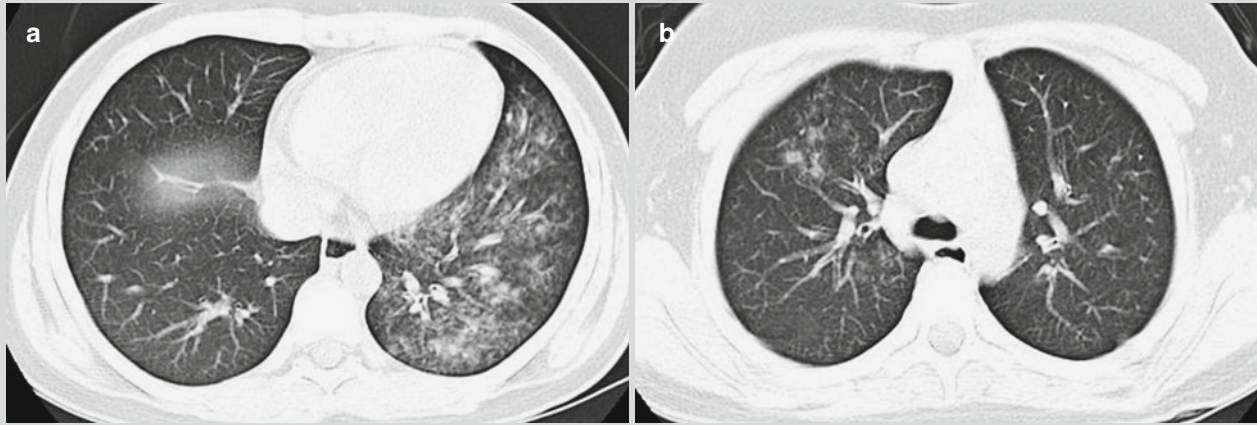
Brucellar pneumonia. (a, b) CT scanning demonstrates multiple ground glass shadows and small nodular shadows in both lungs, suggesting bronchopneumonia
